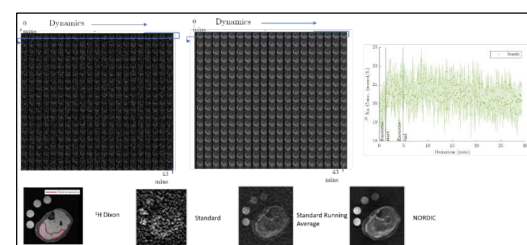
A) *In-vivo* raw running average timeseries of change in sodium in the gastrocnemius muscle in response to exercise. B) ^1H mDIXON image showing gastrocnemius ROI and ^{23}Na images binned over exercise (0:88-5:52mins) and recovery (24:56-30:28mins) periods. C) NORDIC corrected high temporal resolution timeseries showing the change in peak sodium on exercise. B) Timeseries of raw ^{23}Na MRI calf images collected data before and C) after NORDIC.
